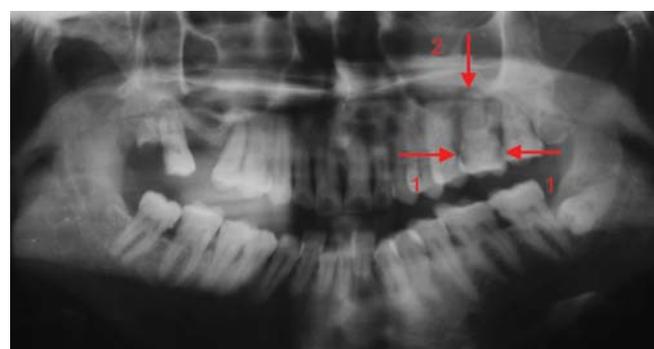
OPG showing proximal caries and periapical lesion of maxillary first molar
